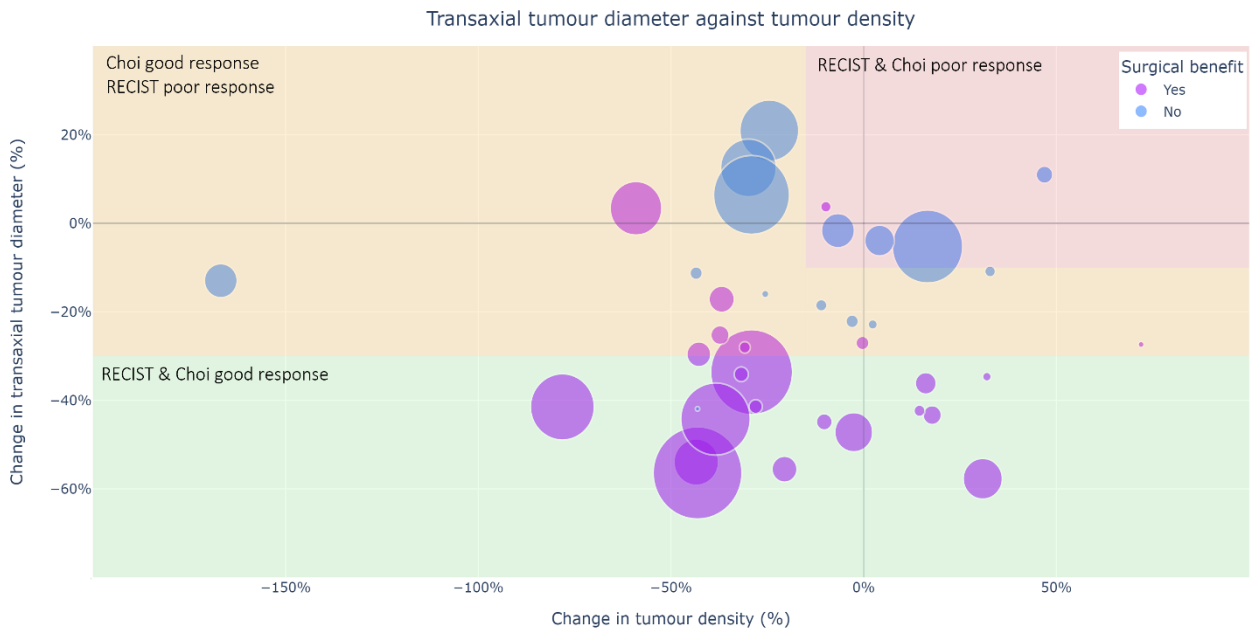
Bubble plot visualising the percentage change in transaxial diameter against the percentage change in tumour density. Each bubble represents an individual non-metastatic GIST patient treated with neoadjuvant TKI treatment. The bubble colour resembles the assessment on surgical benefit (magenta = surgical benefit, blue = no surgical benefit), while the bubble size represents the scaled initial tumour volume at diagnosis. The grid has been divided into three parts by using the thresholds presented in current radiographic response criteria (red = agreement on bad response, green = agreement on good response and orange = discrepancies on responder status).
